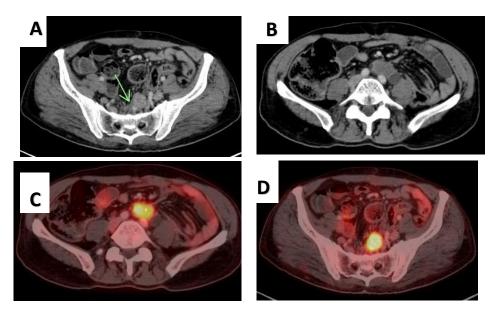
A 50-yr-old male, with ano-rectal adenocarcinoma, received chemotherapy. (A, B) CT images showed enhancing peritoneal soft tissue nodules seen at left deep pelvic and presacral regions as well as just below the aortic bifurcation measuring about 2.5 & 3.5cm respectively showing faint enhancement. (C, D) Fused PETCT images showed metabolically FDG avid peritoneal nodules at the left deep pelvic and presacral (para rectal) lesion measuring about 2.5 cm in width and 6.3 cm in length with SUV max 9.1 as well as at the aortic bifurcation and along the course of the left common iliac artery, the lesion is measuring about 3.5 x 4.4 cm at its max. dimensions with SUV max 8.87. It s encroaching upon / entangling the left ureter with subsequent proximal hydronephrosis.
